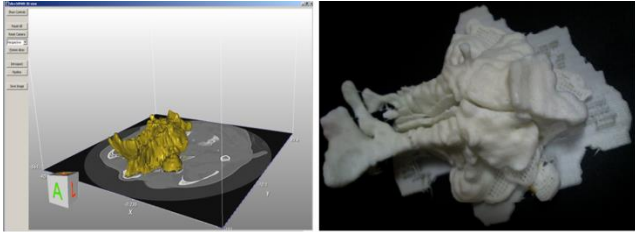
A personalized model of the nasal cavity according to the data spiral computed tomography: a) virtual model; b) natural model.
